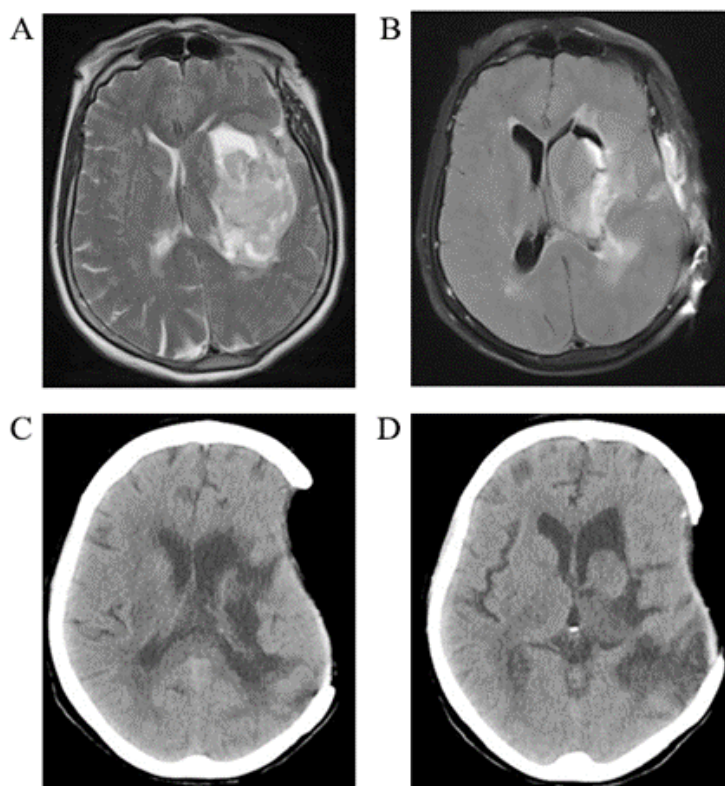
A) Pre-decompression operative MR (T2 Sequence): left lateral ventricular compression due to haemorrhage in the left cerebral hemisphere and right lateral ventricular compression due to shunting; B) Post-decompression operative 24th hour MR (T2 Fair): decrease in shunting and decrease in right lateral ventricular compression 24 hours after the operation C) Post-decompression operative 6th month CT, D) Post-decompression operative 6th month CT: 6 months after the operation, marked improvement of shifting and removal of compression on both ventricles
